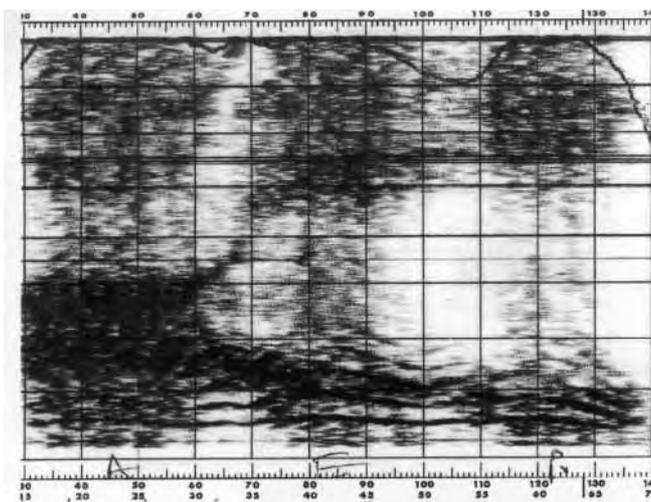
The sonography finding in ventricular voice: vowels a, e, and i
